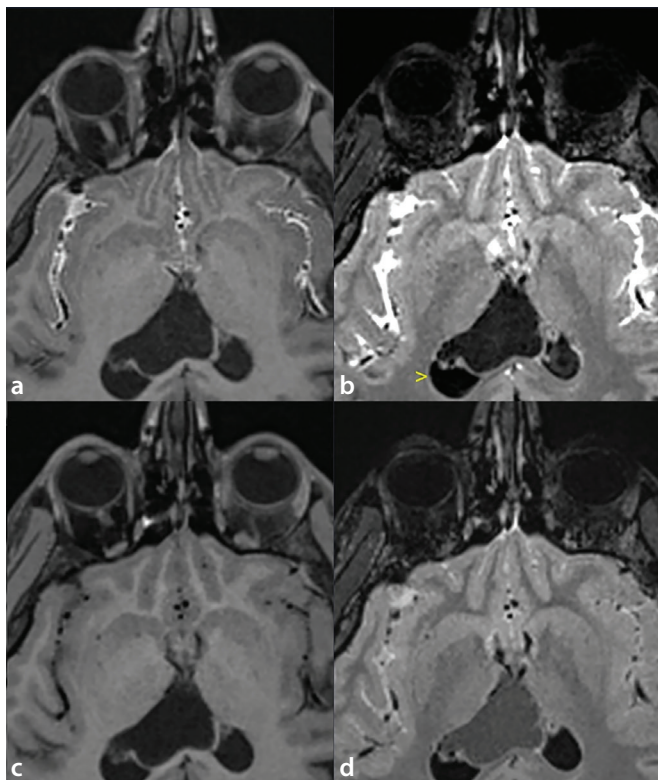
Example of an intraventricular NC-AC based on 3D T1W images. The EP-T1 (a) and LP-T1 (c) images show no opacification (grade 0). The EP-FLAIR image (b) shows no opacification in the occipital horn of the right lateral ventricle (arrowhead) and a faint focal signal increase within the cyst (grade 1). The LP-FLAIR image (d) shows mild partial opacification within the cyst (grade 2). AC, arachnoid cyst; NC, non-communicating; EP, early phase; LP, late phase.
